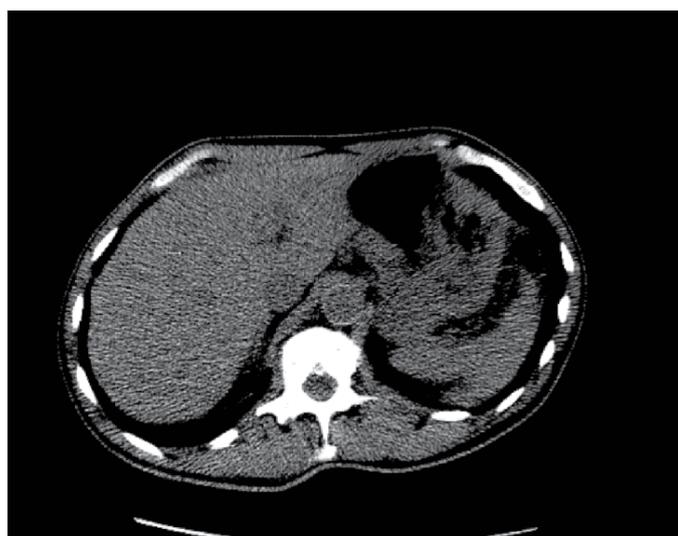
Computed tomography scan of abdomen showing multiple low attenuation lesions in the liver (axial view— Liver window).
